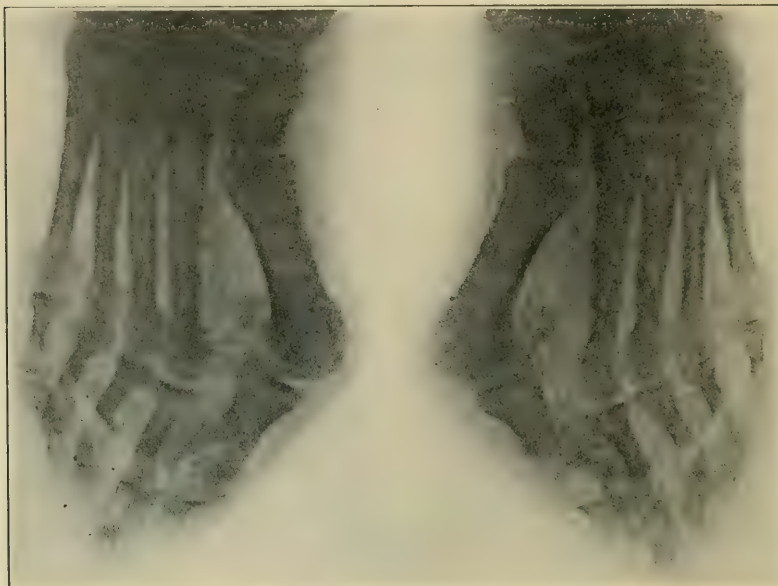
Deformity as shown by radiograph.
